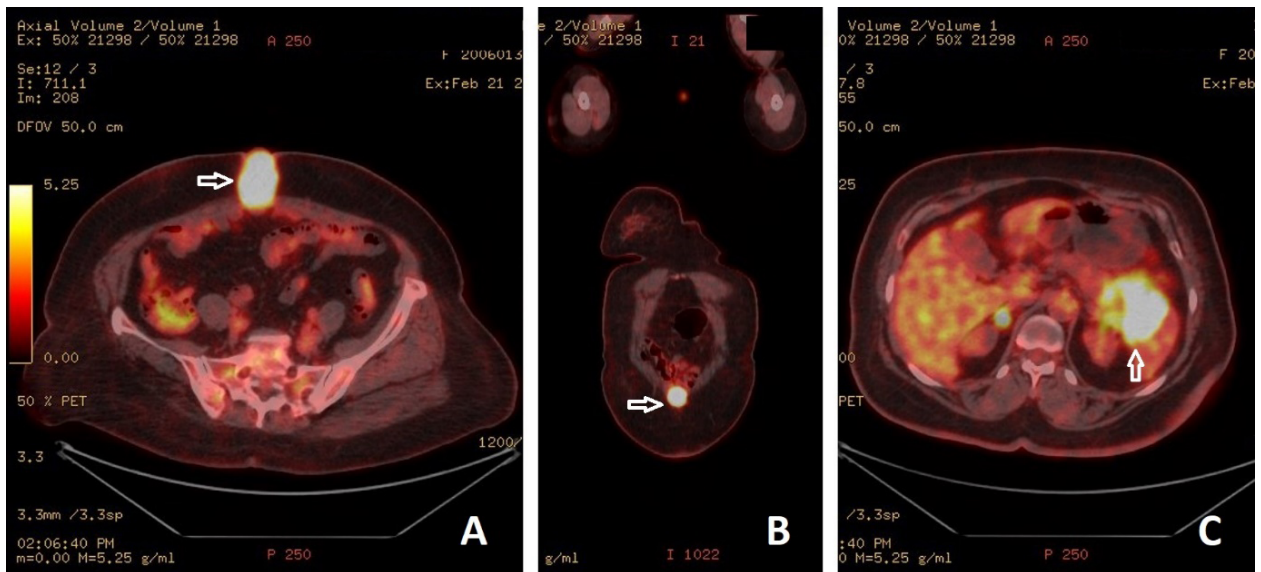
PET/CT axial (A) and coronal (B) sections show the appearance of SMJN, and the axial section (C) shows the tumoral lesion (Arrows) in the tail of the pancreas
